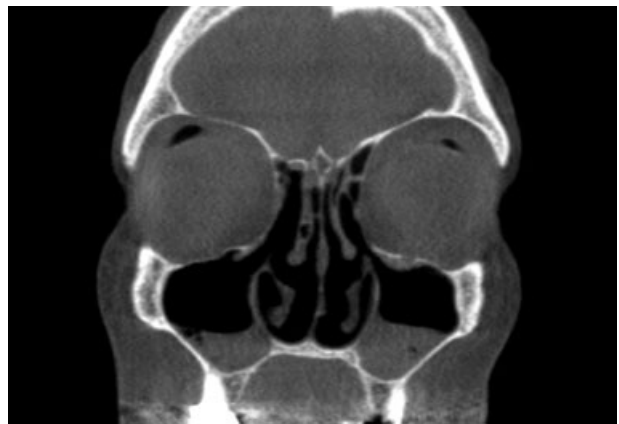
Three-month postoperative sinus CT scan* frame demonstrating bilateral maxillary sinus air-fluid levels, and the postsurgical changes of the ethmoid surgery. A sinus CT scan was performed because of the maxillary sinus floor inspissated mucous found on nasal endoscopy in ►Fig. 3. The patient's only symptom complaint was postnasal drainage and cough. Both maxillary sinuses were suctioned of inspissated mucous and sent for culture. Same appointment as ►Fig. 2. The cultures showed no growth of bacteria. * Three hundred frame scans performed in this study using 0.09 mSev. Xoran MiniCAT™ Low Dose CT (MiniCAT™ Effective dose estimates. 5210 S. State Rd., Ann Arbor, MI 48108).
